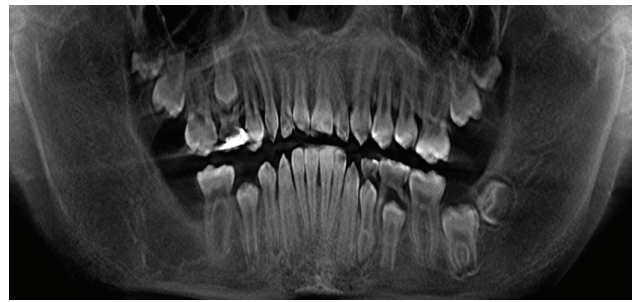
Post-operative control orthopantomography is presented one year after the surgical intervention, where adequate bone tissue formation is observed in the cavity
